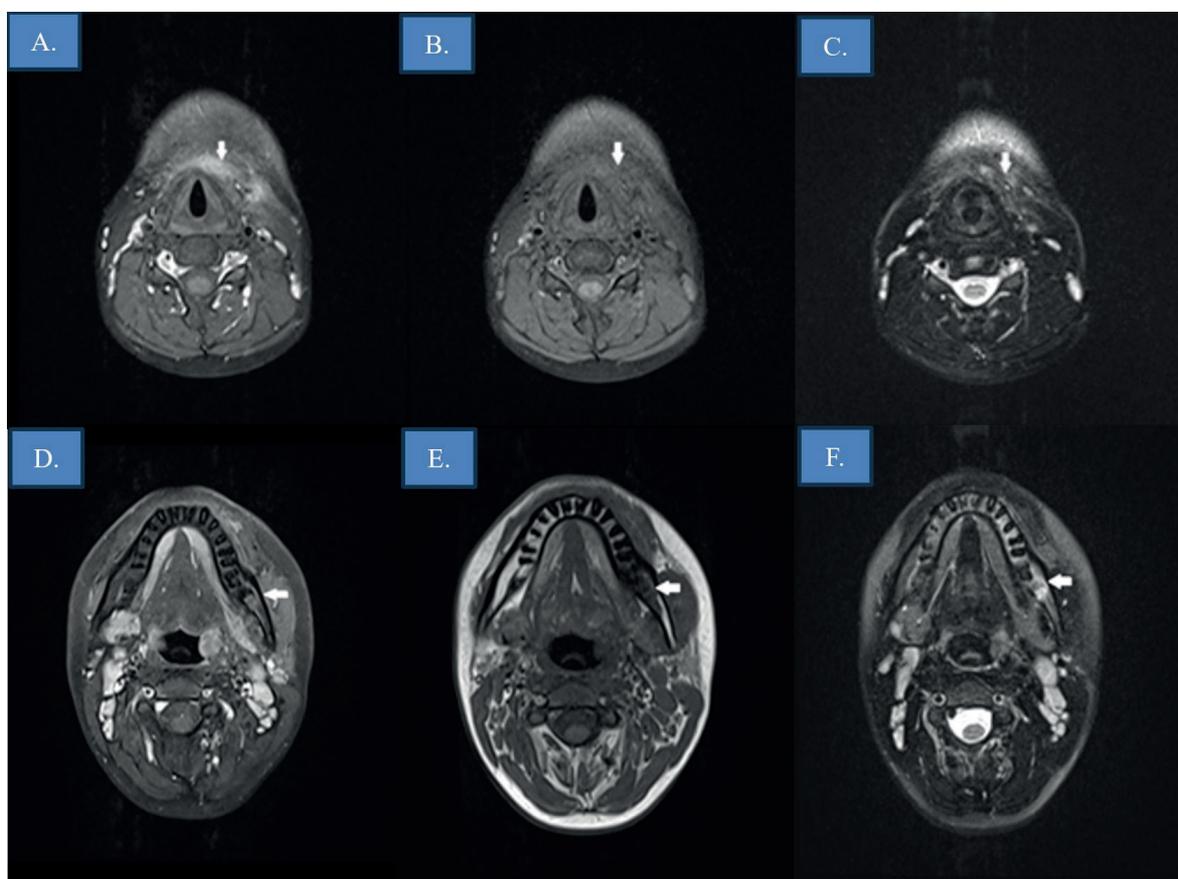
Magnetic resonance imaging (MRI) showing altered signal intensity in the left mandibular ramus consistent with osteomyelitis and a 13 × 9 mm phlegmon in the anterior neck adjacent to the hyoid bone A and B. Axial T1-weighted fat-suppressed post-contrast images demonstrates diffuse inflammatory soft-tissue changes, consistent with phlegmon (arrows). C. Axial T2-weighted fat-suppressed MRI demonstrates a diffuse area of high signal intensity in the subcutaneous and deep cervical soft tissues (arrow), consistent with a phlegmon. D. Axial T1-weighted fat-suppressed post-contrast image demonstrates intense enhancement and marrow signal abnormality along the mandibular body (arrow), consistent with osteomyelitis. E. Axial T1-weighted MRI shows low signal intensity in the cortical and medullary portions of the mandibular bone (arrow), consistent with osteomyelitis. Adjacent soft-tissue inflammatory changes are also present. F. Axial T2-weighted fat-suppressed image shows hyperintense marrow signal and surrounding soft-tissue edema along the mandibular body (arrow), consistent with osteomyelitis.
